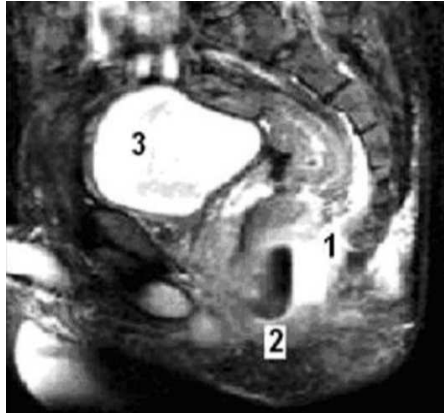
MRI with contrast enhancement of the rectum. Acute ischioanal paraproctitis: 1 – abscess cavity; 2 – primary purulent passage; 3 – bladder (indicated by numbers).
